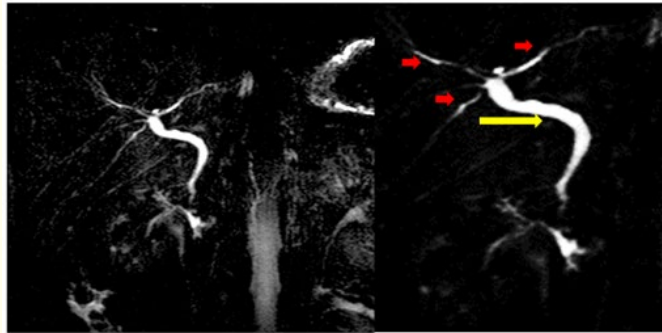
Cholangio-MRI shows the absence of the gallbladder and cystic duct with normal calibre of the bile duct (yellow arrow) in its proximal part. The intrahepatic bile ducts (red arrows) are of normal calibre.
